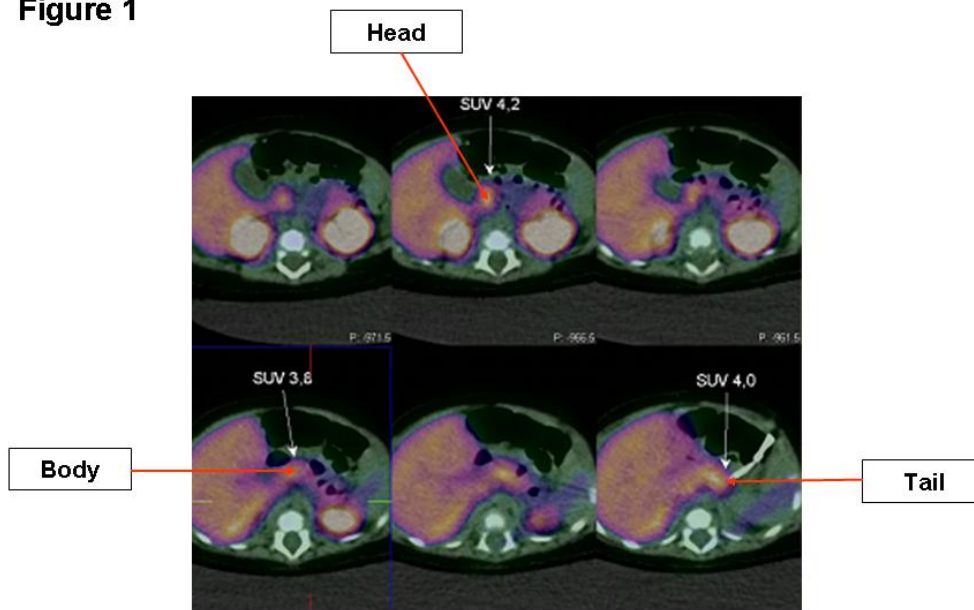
^{18}F -L-DOPA-PET/CT scan showing uptake of the ^{18}F -L-Dopa throughout the whole of the pancreas in patient 1. The principle of this test is that, pancreatic islets take up L-3, 4-dihydroxyphenylalanine (L-DOPA), and convert it to dopamine by dopa decarboxylase, present in the islet cells. The SUV (standard uptake value) reflects the intensity of uptake of DOPA. The ^{18}F -L-DOPA-PET/CT scan in this patient shows uniformly (in the head, body and tail of pancreas) increased uptake of ^{18}F -L-Dopa reflecting increased metabolic activity of the islets. The intensity of uptake of the ^{18}F -L-Dopa by the islets was equivalent to that observed in patients with defects in pancreatic K_{ATP} channels (7). This fits in with the clinical observation of severe hyperinsulinaemic hypoglycaemia.
